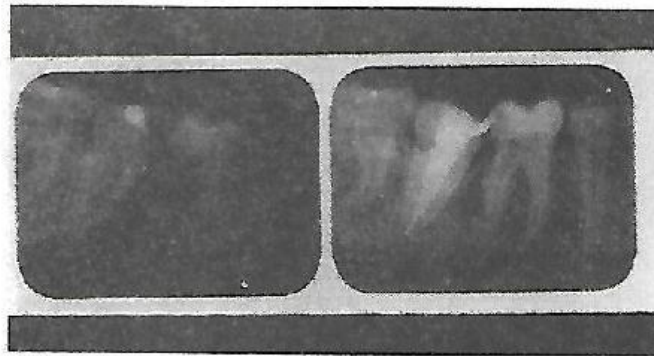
Case Report 2 (A. Pre-operative radiograph and B. Post-operative radiograph).
